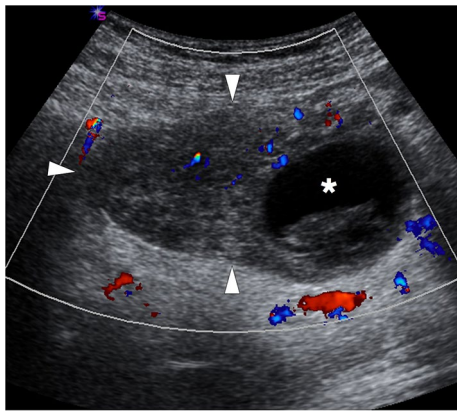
A 33-year-old female patient presented with acute onset abdominal pain in the right lower quadrant. Color Doppler US showed an asymmetrically enlarged right ovary with heterogeneous stroma (arrowheads) and diminished-(but still preserved) parenchymal vascularity. Clinical and radiological findings were found to be consistent with ovarian torsion. Also, note was made of a peripherally located hemorrhagic cyst (asterisk), which was thought to be the culprit focus for the ovarian torsion. This ovary was surgically detorsed in emergency surgery
